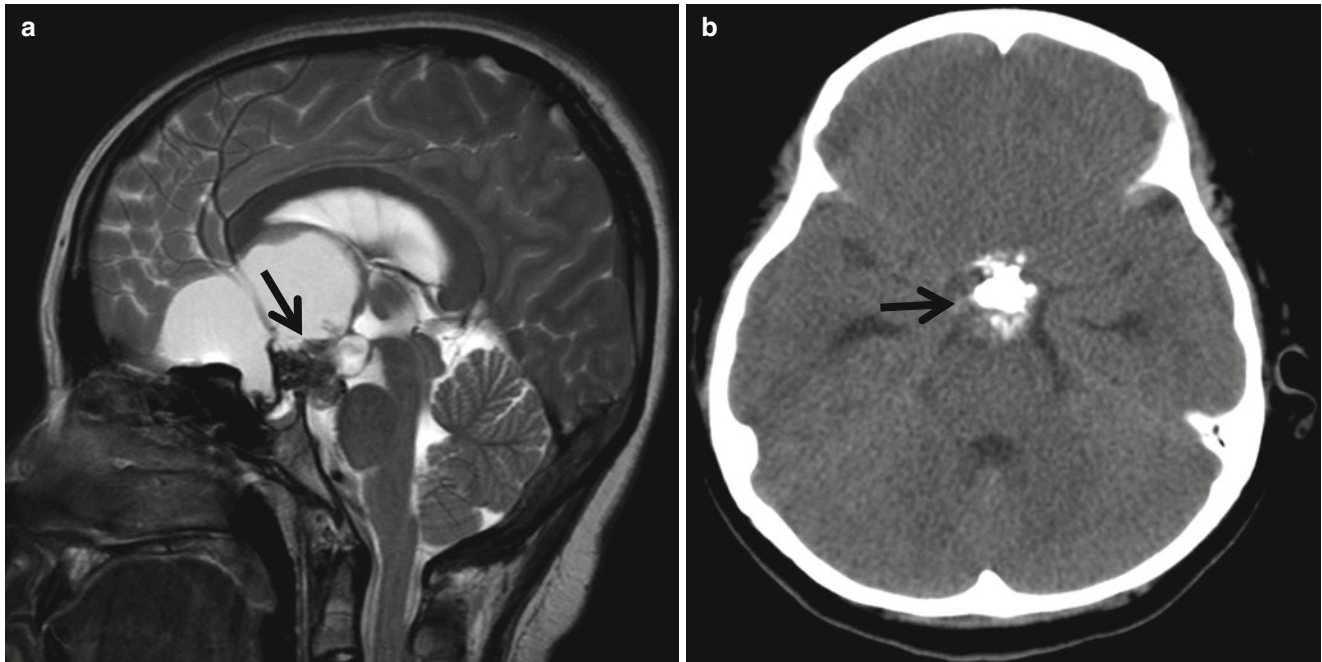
Craniopharyngioma in a 15-year-old girl. (a) T2-weighted sagittal image shows large cystic and solid mass at the suprasellar area. Small solid portion is containing dark intensity (*arrow*), suggesting
